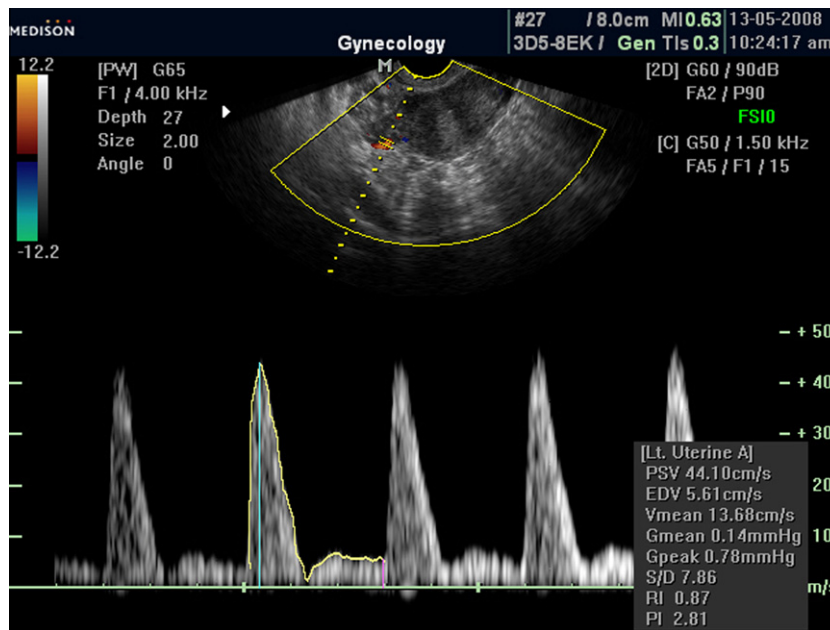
Doppler study of the uterine artery (left) in a case documented to have adenomyosis.
